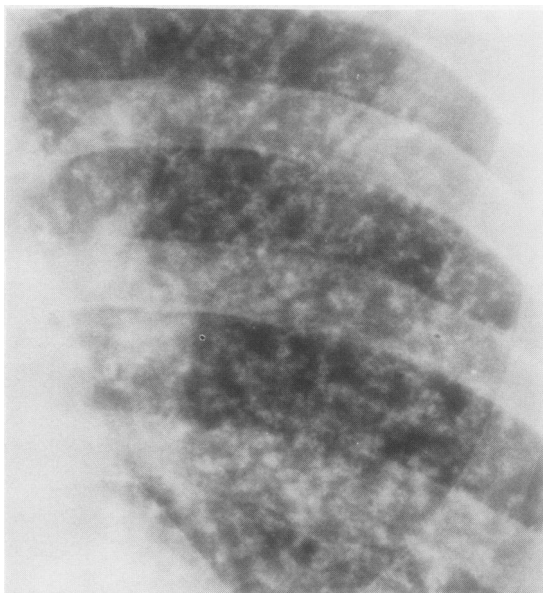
Close up view of radiograph of a man with baritosis, showing fine nodular and small ring shadows suggestive of intra-alveolar and intrabronchiolar deposition of dust.
